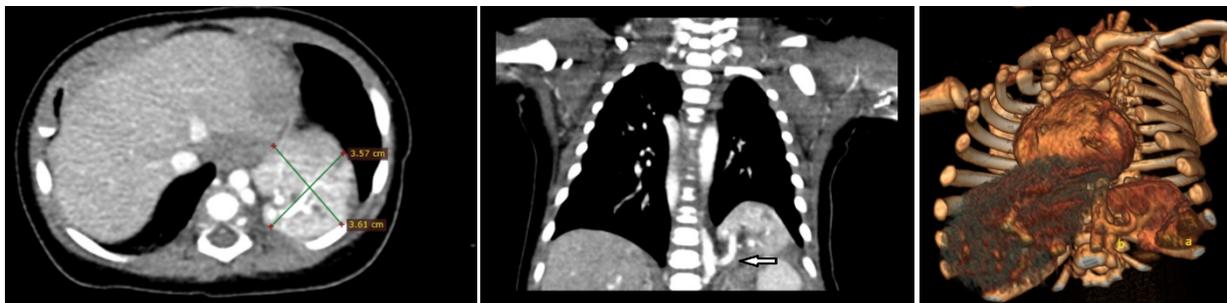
A, B, C. Contrast enhanced thoracic CT scan with 3D reconstruction. Tumor is situated at the base of the left lung. Vascularisation from the descending aorta
